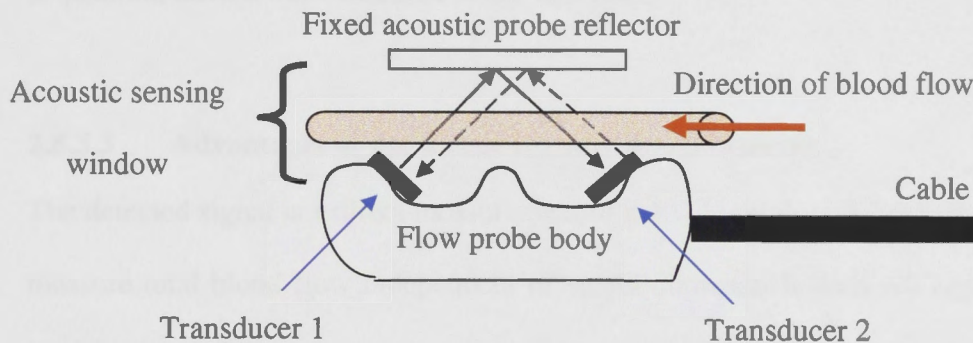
Basic structural components of an ultrasonic perivascular ultrasonic volume flow-sensing probe. \longrightarrow upstream transit-time cycle, $-\ - \longrightarrow$ downstream transit-time cycle.
